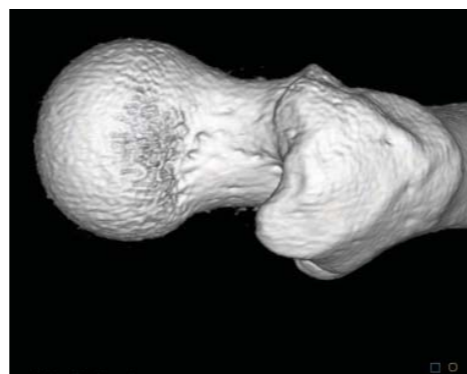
3D surface rendered CT image of a normal left femoral head and neck for preoperative surgical planning. Note the shape of the femoral head and neck junction both anteriorly and posteriorly.
